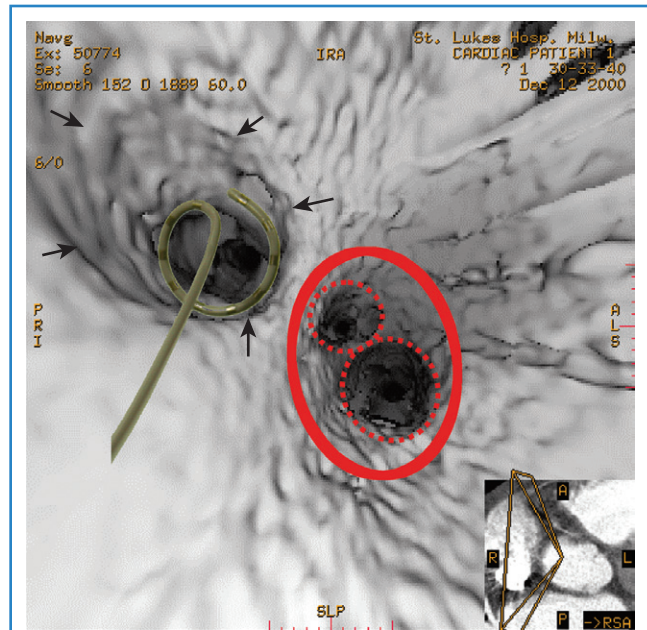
Endocardial computed tomography image showing pulmonary veins and different techniques of pulmonary vein isolation. A multi-electrode catheter is positioned in the upper pulmonary vein. Bottom vein shows circumferential isolation techniques used during atrial fibrillation ablation.
